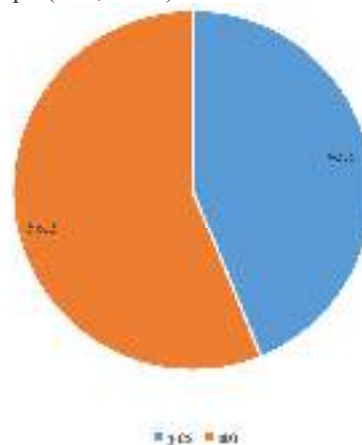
Proportions of participants prescribing bitewing radiographs to patients in their practice
